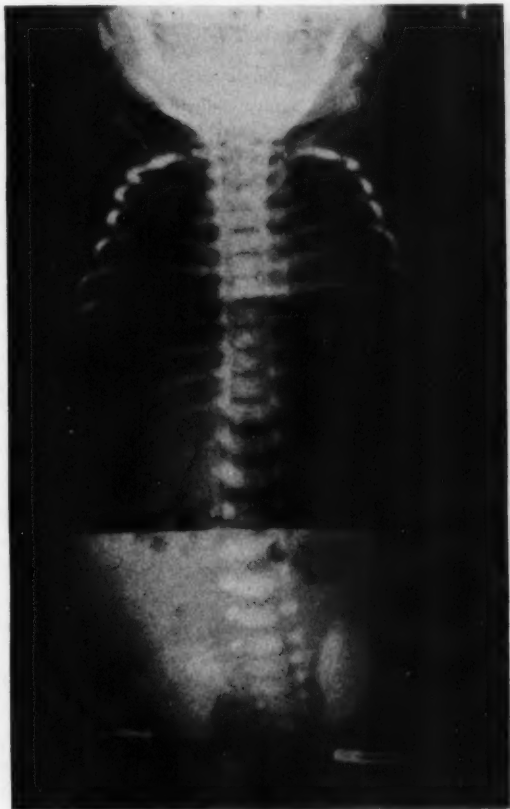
Erect Roentgenograms revealing marked pneumoperitoneum. The liver has been forced downward and medially by air under the diaphragms. A fluid level is present. Air-containing segments of bowel can be seen throughout the abdomen.
